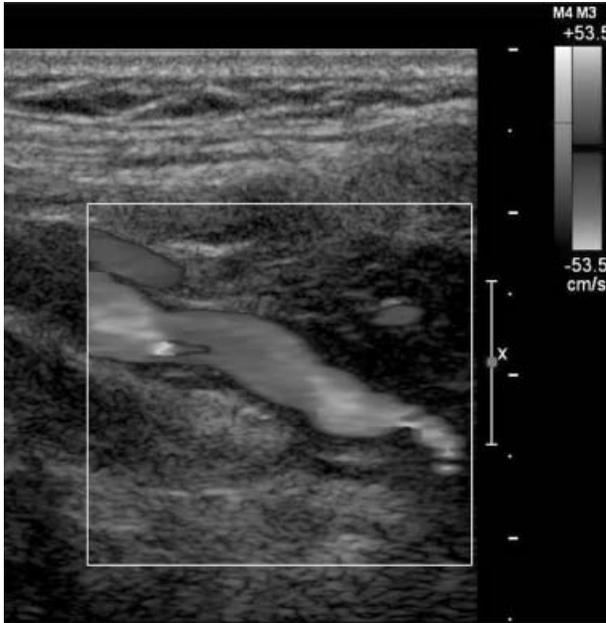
Carotid duplex ultrasonography of the right internal carotid artery shows alternating regions of lumen narrowing and vessel dilation several centimetres distal to the carotid bifurcation.
